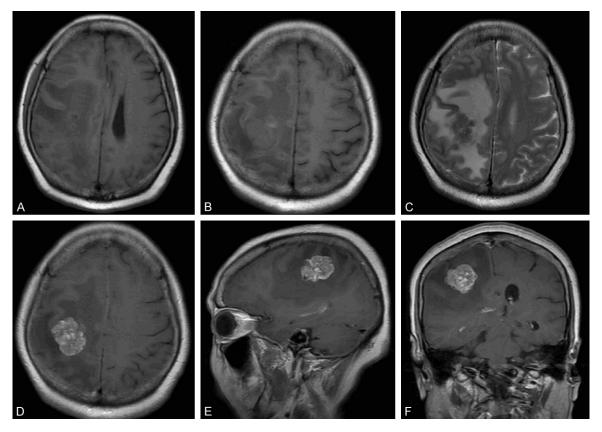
(A, B) Axial T1-weighted MRI reveals a 33*31*28 mm isointense mass in the right parietal region. (C) Axial T2-weighted MRI shows a hypointense mass. (D) Axial, (E) Sagittal and (F) Coronal enhanced T1-weighted MRI shows a mulberry enhancement mass with obvious brain edema.
